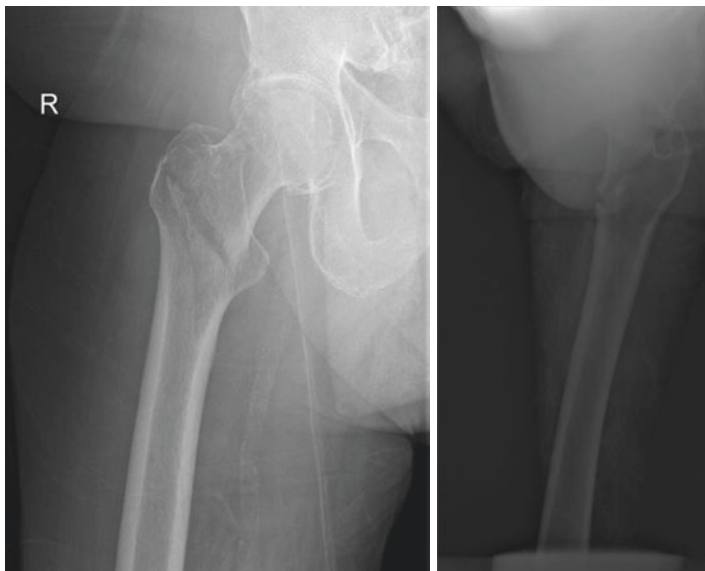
I Representative radiographic images of intertrochanteric fractures
